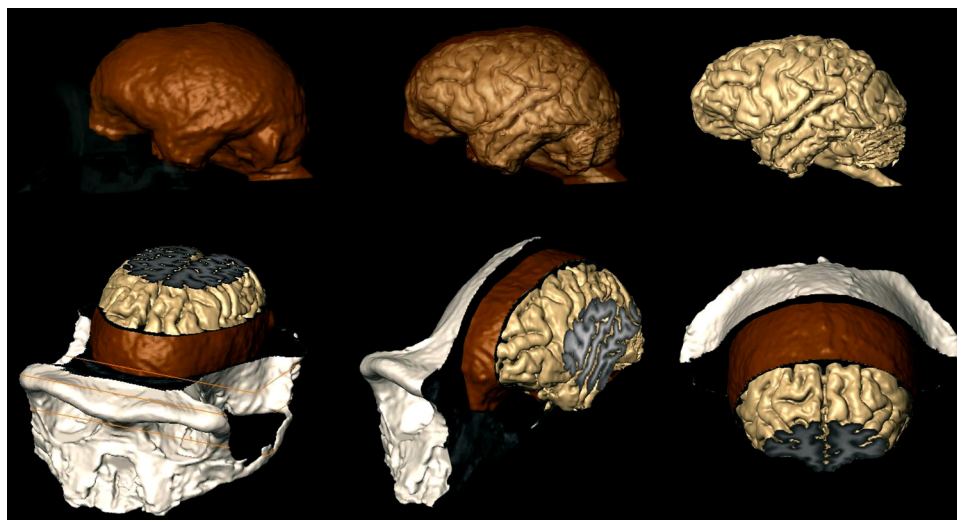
MRI techniques used to study the brains of chimpanzees (Semendeferi et al., 2002), can now investigate the relationship between the brain and the endocranium as shown here. Brain is beige; endocranium is
